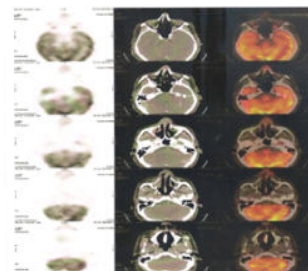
Image of post operative PET-CT SCAN
